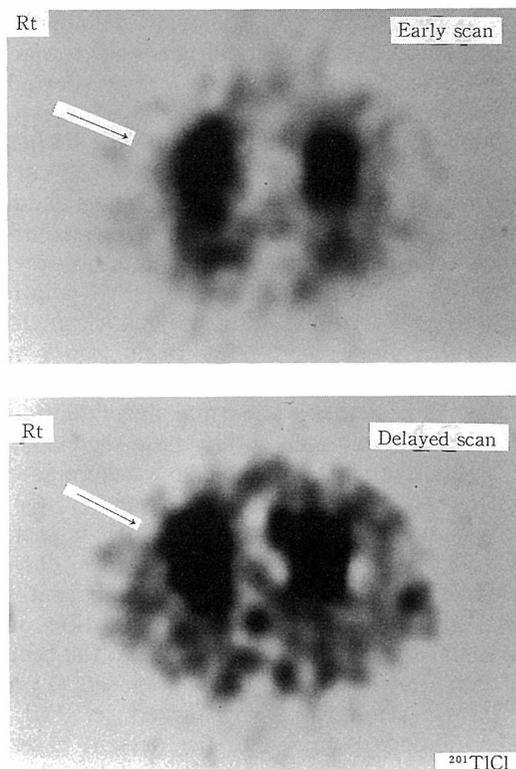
Early and delayed images of $^{201}\text{TlCl}$ SPECT showed intensive uptake in the lesion, with the uptake ratios of 1.75 and 2.30, respectively. The retention index calculated by both uptake ratios was 31.4%.
